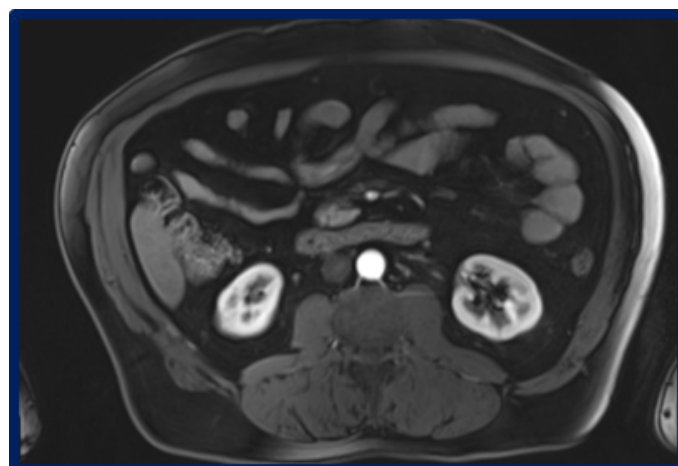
Abdomen MRI done at the end of the chemotherapy confirming the disappearance of retroperitoneal lymph nodes.
